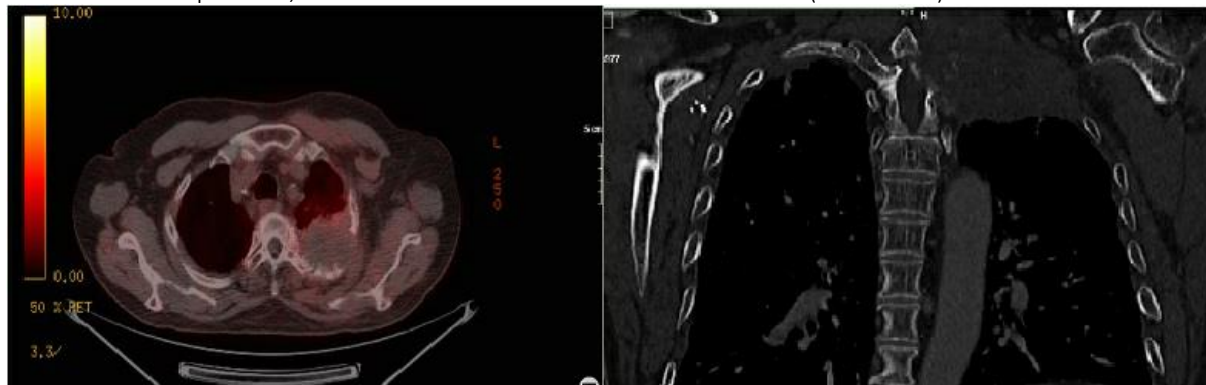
A decrease in terms of metabolic activity and diameter of tumor was detected on PET-CT taken after the chemo-radiotherapy. PET/BT axial and thorax CT coronal section image after chemo-radiotherapy.
